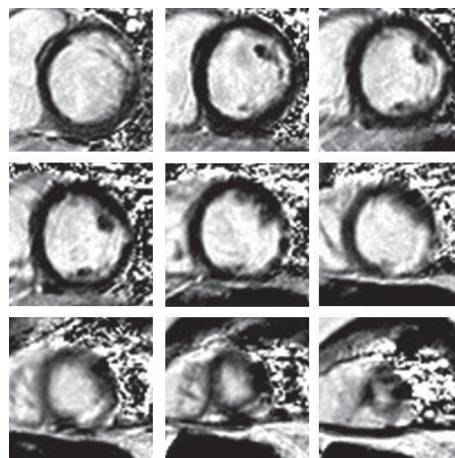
Short axis MRI images from basis (upper left) to apex (lower right), demonstrating late enhancement in the lateral wall.
